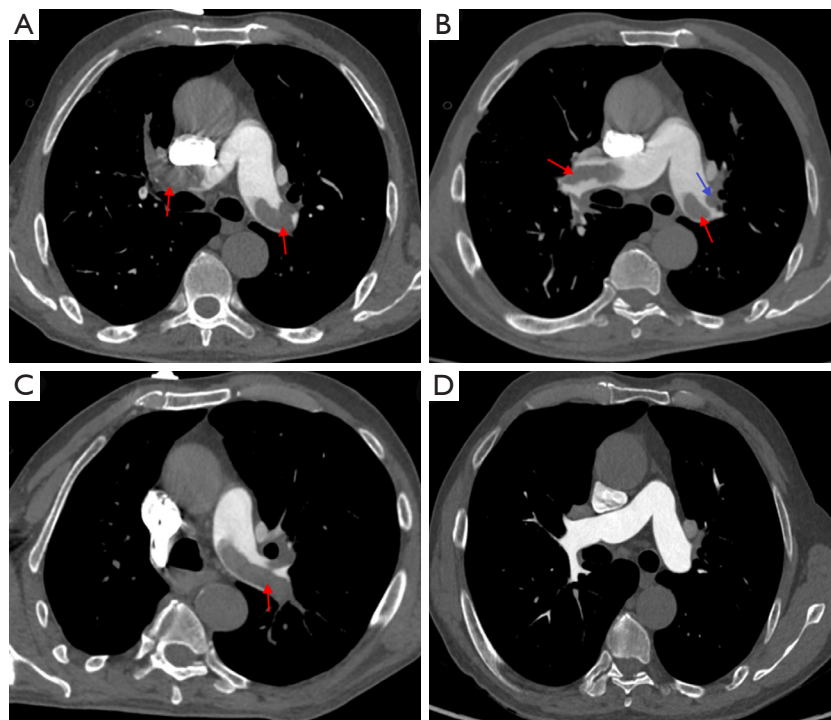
A 67-year-old man with sudden syncope and deep vein thrombosis of the lower limbs was clinically diagnosed with acute pulmonary thromboembolism. (A) CTPA axial imaging showed filling defects in the bilateral pulmonary arteries (red arrows). (B,C) CTPA oblique axial images showed emboli floating in the lumen of the pulmonary artery with a tubular (red arrows) or polypoid (blue arrow) shape. (D) One month after anticoagulant therapy, CTPA axial imaging showed that the filling defects in the bilateral pulmonary arteries had significantly reduced. CTPA, computed tomography pulmonary angiography.
